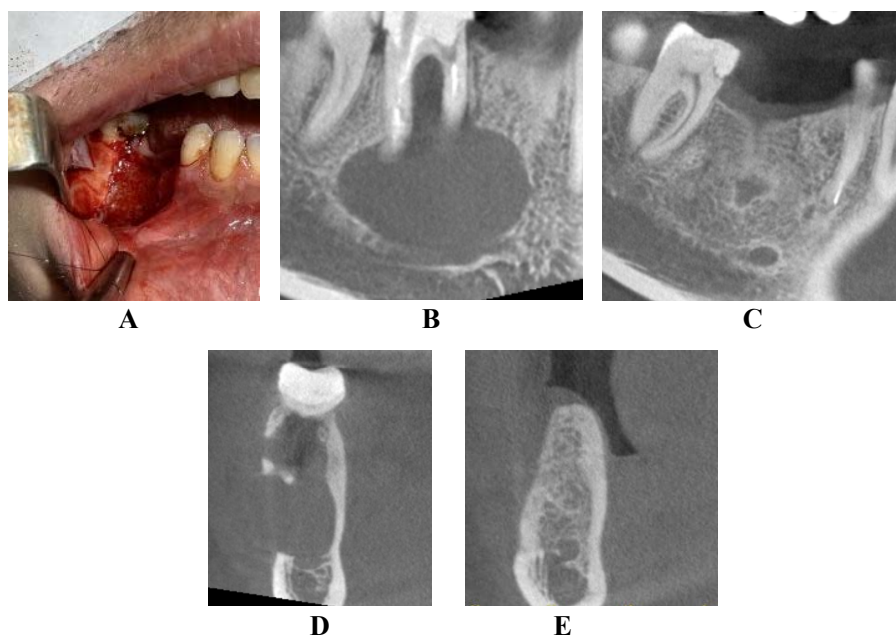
Patient L., 28 years old. Diagnosis: radicular cyst of the lower jaw on the right in the area of tooth 46. Condition of the patient 8 months after cystectomy and bone grafting in the area of the lower right molars. X-ray examination (computed tomography): A – surgical intervention; B – panoramic scan (before surgery); C – panoramic scan (after surgery); D – transverse reconstruction of the defect site (before surgery); E – transverse reconstruction of the defect site (after surgery).
